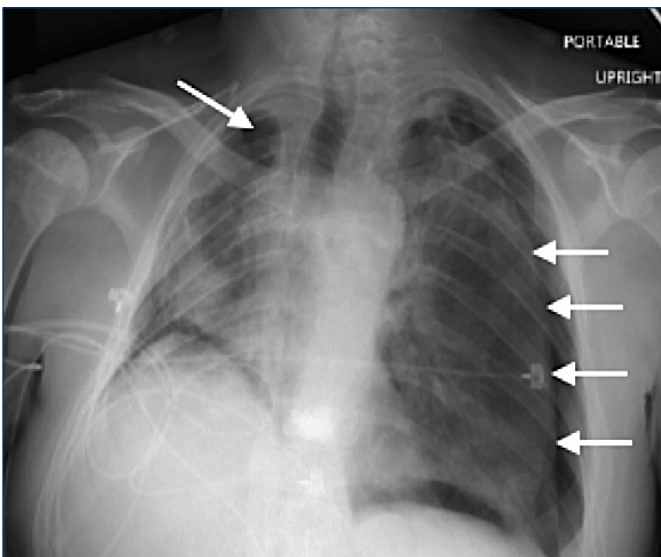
Chest X-ray HD7 showing bilateral pneumothoraces (border of pneumothoraces marked by white arrows)
